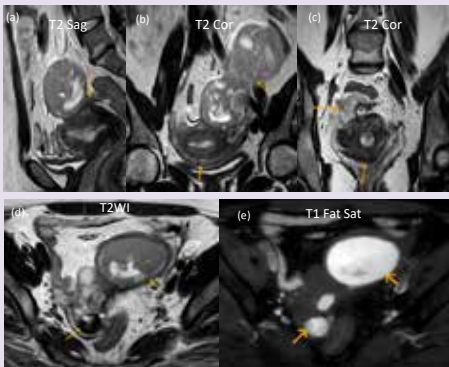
The MR imaging revealed an endometriotic plaque in the region of torus uterinus, with adherence of anterior wall of the rectum in this region (a). The bilateral adnexal structures were displaced medially and adherent to the uterus, representing sequelae of deep pelvic endometriosis (b & c). Bilateral ovarian endometriotic cysts were seen, appearing hyperintense on T1WI and showing T2 shading (d & e).
